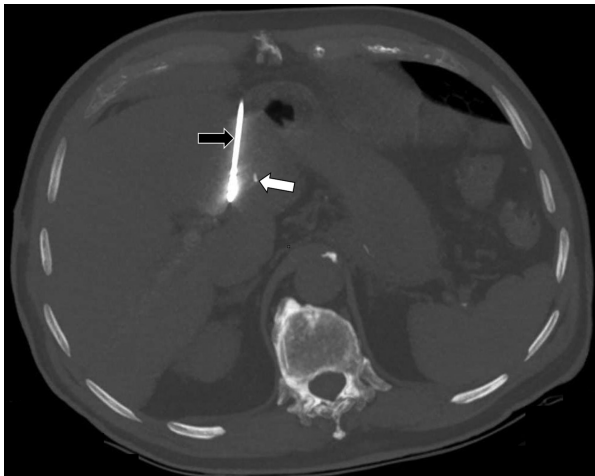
Non-enhanced computed tomography (CT) during ablation. Ablation antenna (*black arrow*) and the marker (*white arrow*).
